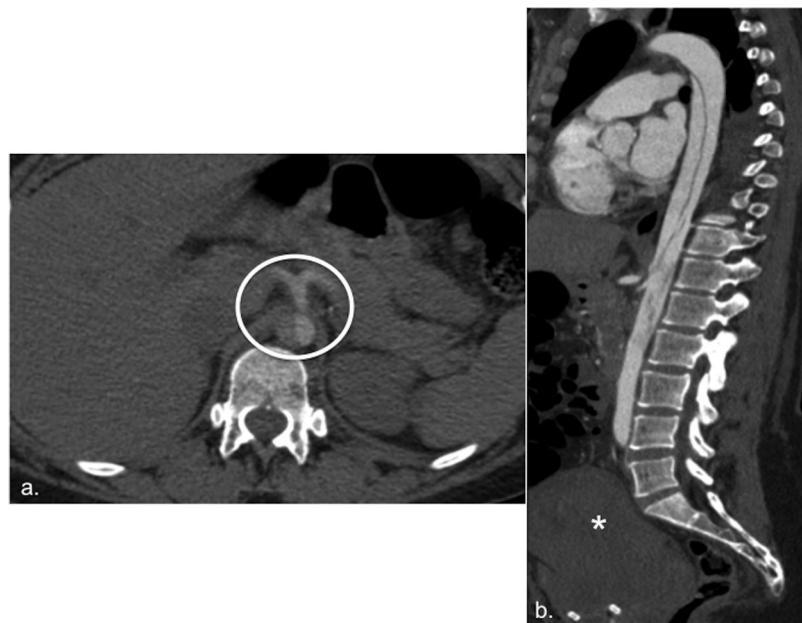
A 38-year-old woman on the second day following an emergency Caesarian birth due to pre-eclampsia, with signs and symptoms of sudden-onset epigastric pain. A CT angiogram of the chest was performed due to suspicion of pulmonary thromboembolism. The last slice from the CT of the chest (a) shows dissection of the descending aorta (circle). The study was complemented with CT of the aorta (b) which confirmed Stanford type B aortic dissection and showed the puerperal uterus (*).
